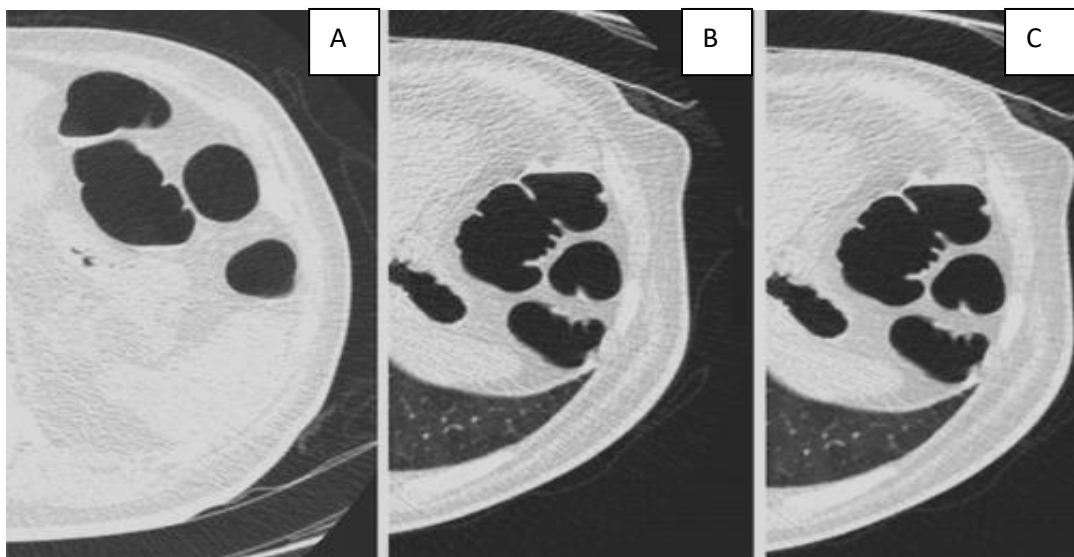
Image in the axial plane at the level of the splenic flexure of the colon. (A) CT colonography performed in the supine position using a standard current of 50 mAs; no ASIR. (B) CT colonography image in the prone position using 25 mAs and 40% ASIR. (C) ASIR reduces the noise index providing a good image [9].
